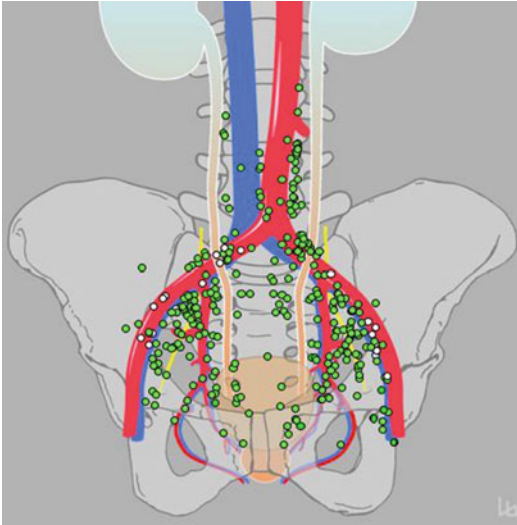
Primary landing sites of the prostate [20]. Lymph nodes depict three-dimensional reconstruction of SPECT/CT/MRI data sets confirmed by intraoperative detection with a gamma probe. Green coded lymph nodes were visualized on direct view. White coded lymph nodes were located behind the represented vascular structures
